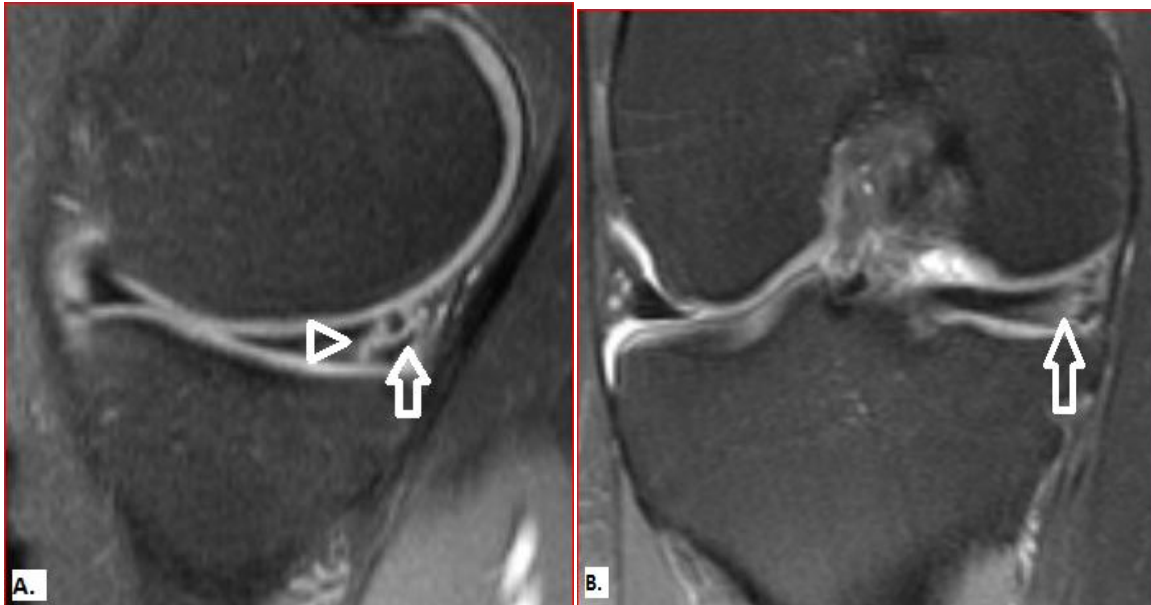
MRI appearance of menisco capsular separation. (A.) PD fat sat weighted coronal image shows interposition of fluid between lateral meniscus and lateral collateral ligament (arrow).
